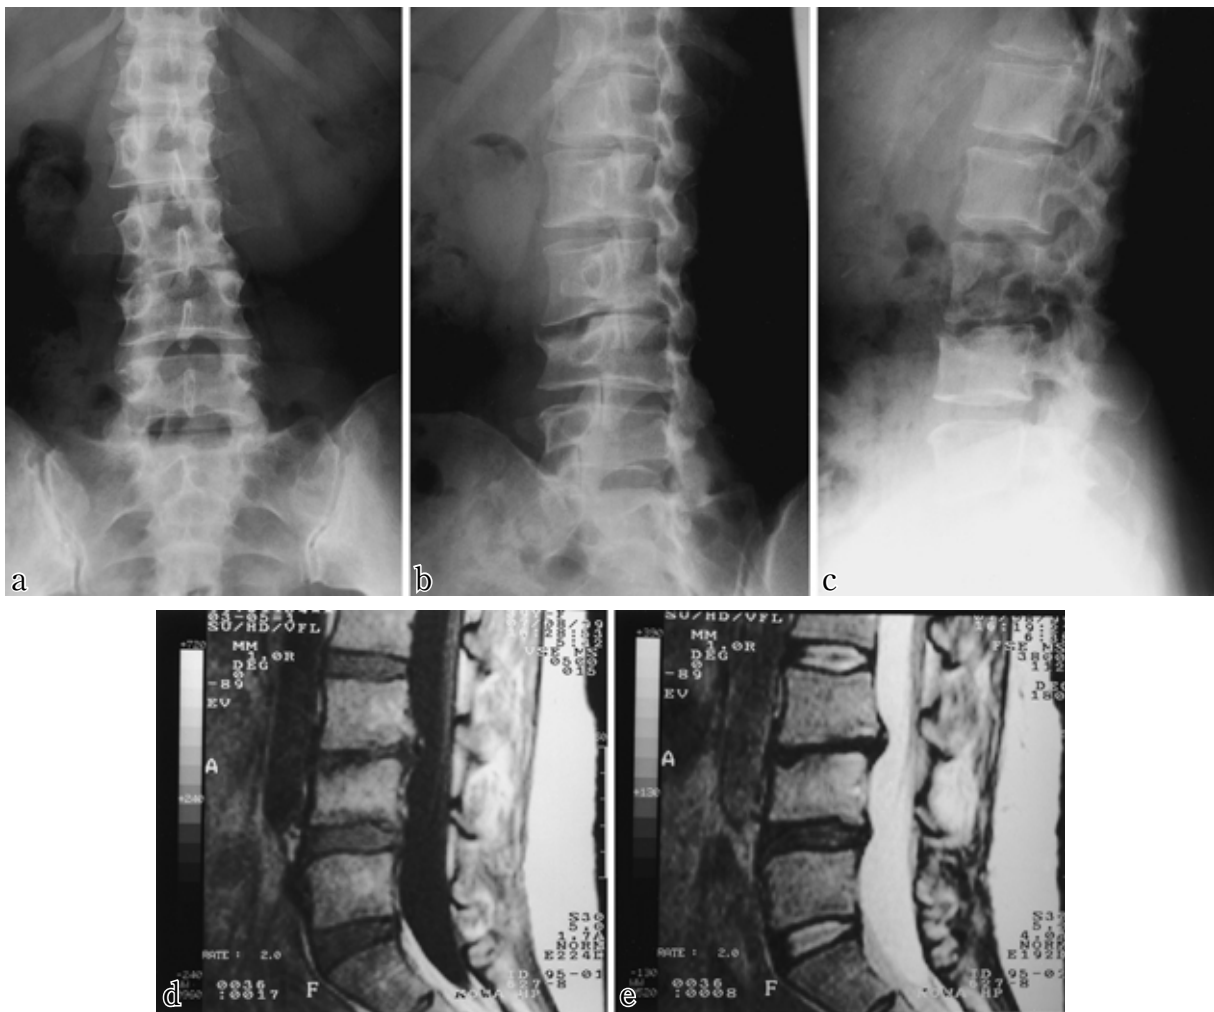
Radiographs and MRI (July 1999). There was an improvement in X-ray examination, MRI and bone scintigram findings. Fig. 8-a: AP view, Fig. 8-b: Oblique view, Fig. 8-c: Lateral view, Fig. 8-d: MRI T 1-weighted image, Fig. 8-e: MRI T 2*-weighted image.
